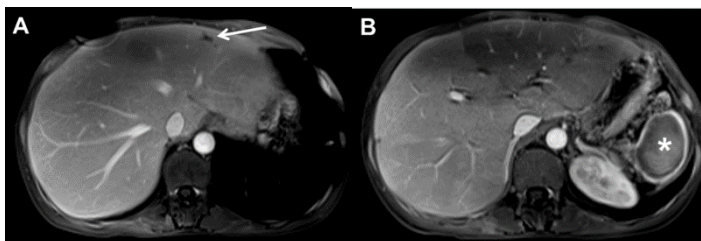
Contrast-enhanced fat-sat hepatic venous phase T1 weighted (A and B) MR images show a subsegmental hepatic infarct (arrow) with hypoperfused portion in left lobe. Post-contrast T1 weighted (B) MR image also demonstrates a large, global infarct (asterisk) of the spleen with only a tiny amount of enhancing splenic tissue (rim sign).
